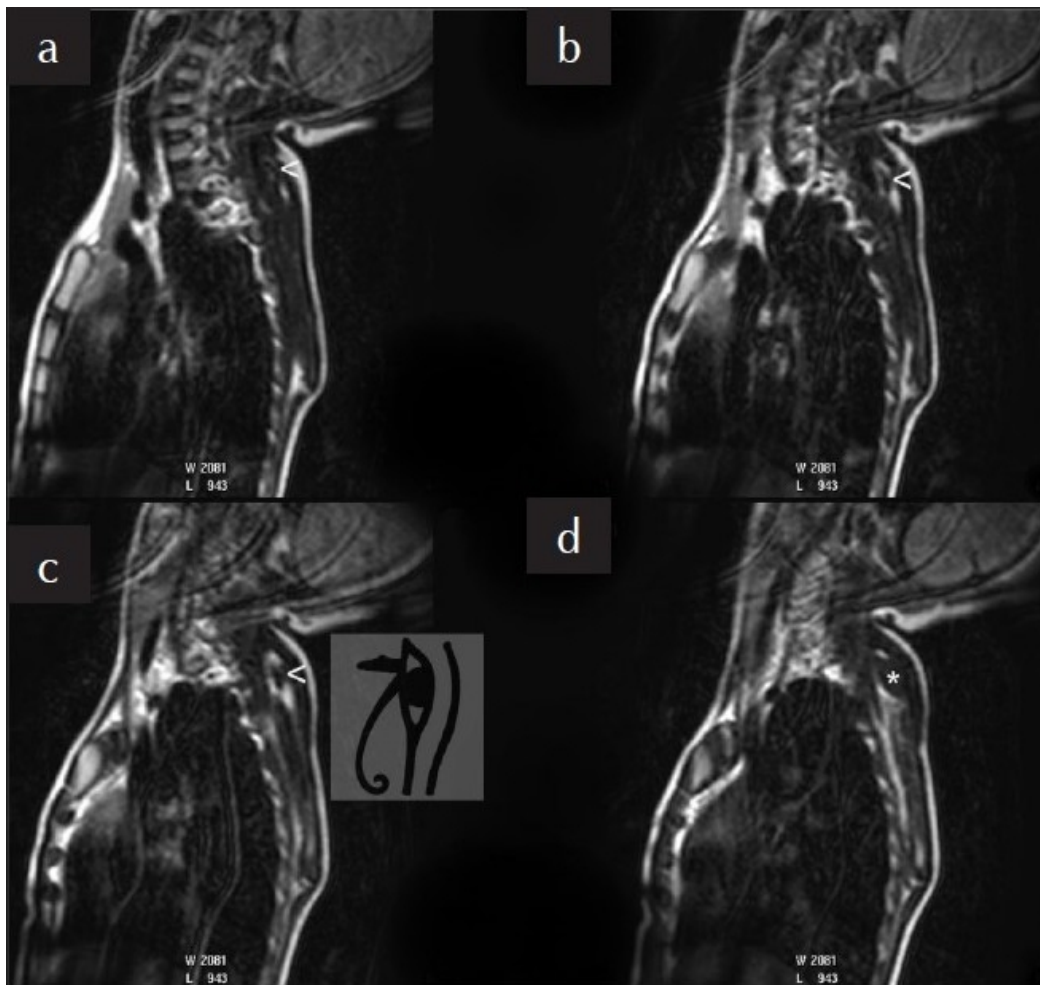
Sagittal MR image series (a, b, c, d) demonstrate the omovertebral band. (c) Omovertebral band and peripheral fat tissue both look like an eye. * Points to the superomedial angle of the right.
